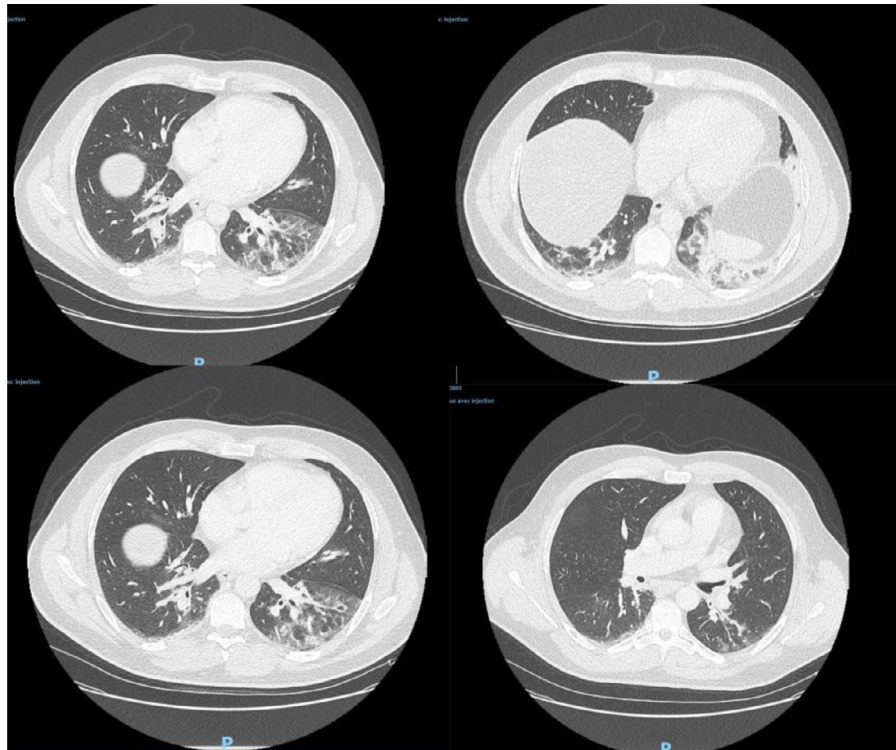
Chest computed tomography (CT) images at baseline. Bilateral pulmonary ground-glass opacities appear in the inferior lobes.
